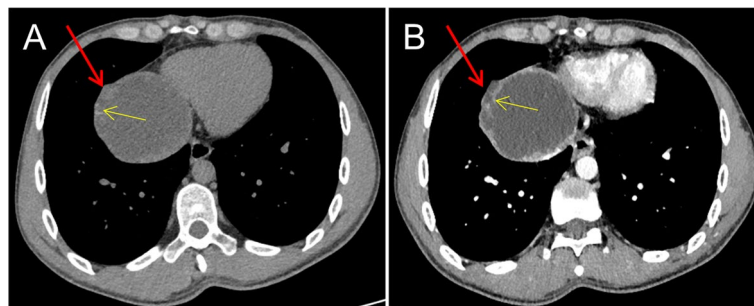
Imaging findings. An MDCT shows a cystic low-density mass on the right outer side of the right atrium (red arrow). B CTA of the thoracic aorta showed mild enhancement of the lesion's margins, with small vesicle hypodense shadows around it (red arrow). The yellow arrow indicates small vesicles
